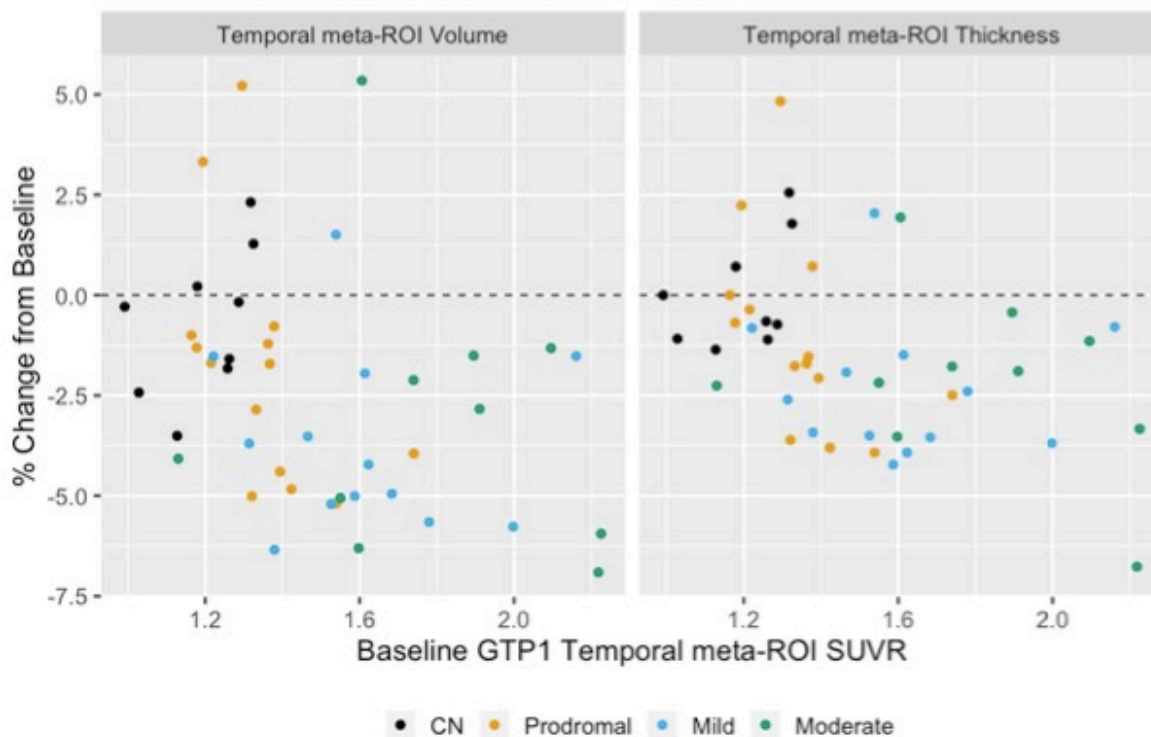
Percentage change from baseline in temporal meta-ROI volume and thickness plotted against baseline $[^{18}\text{F}]\text{GTP1}$ SUVR. Cognitive Normal: black; Prodromal: orange; Mild: blue; Moderate: green.
